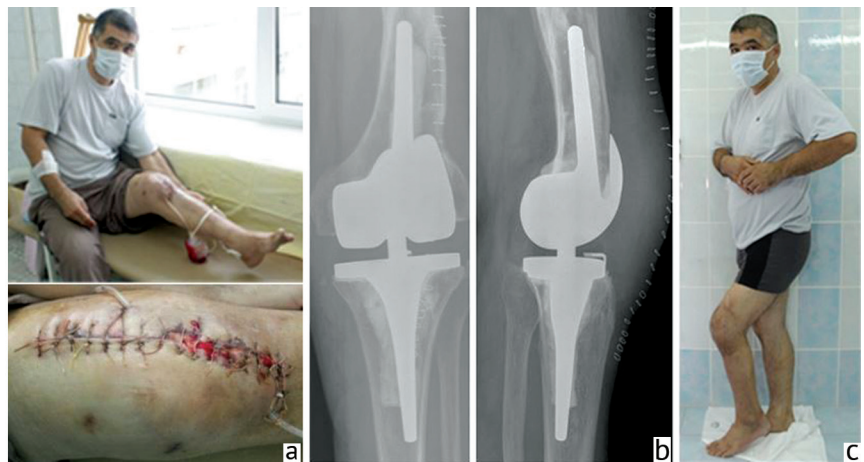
Patient S.: *a* appearance after surgery, drainage stage; *b* radiographs of the knee after revision arthroplasty; *c* photo after treatment
